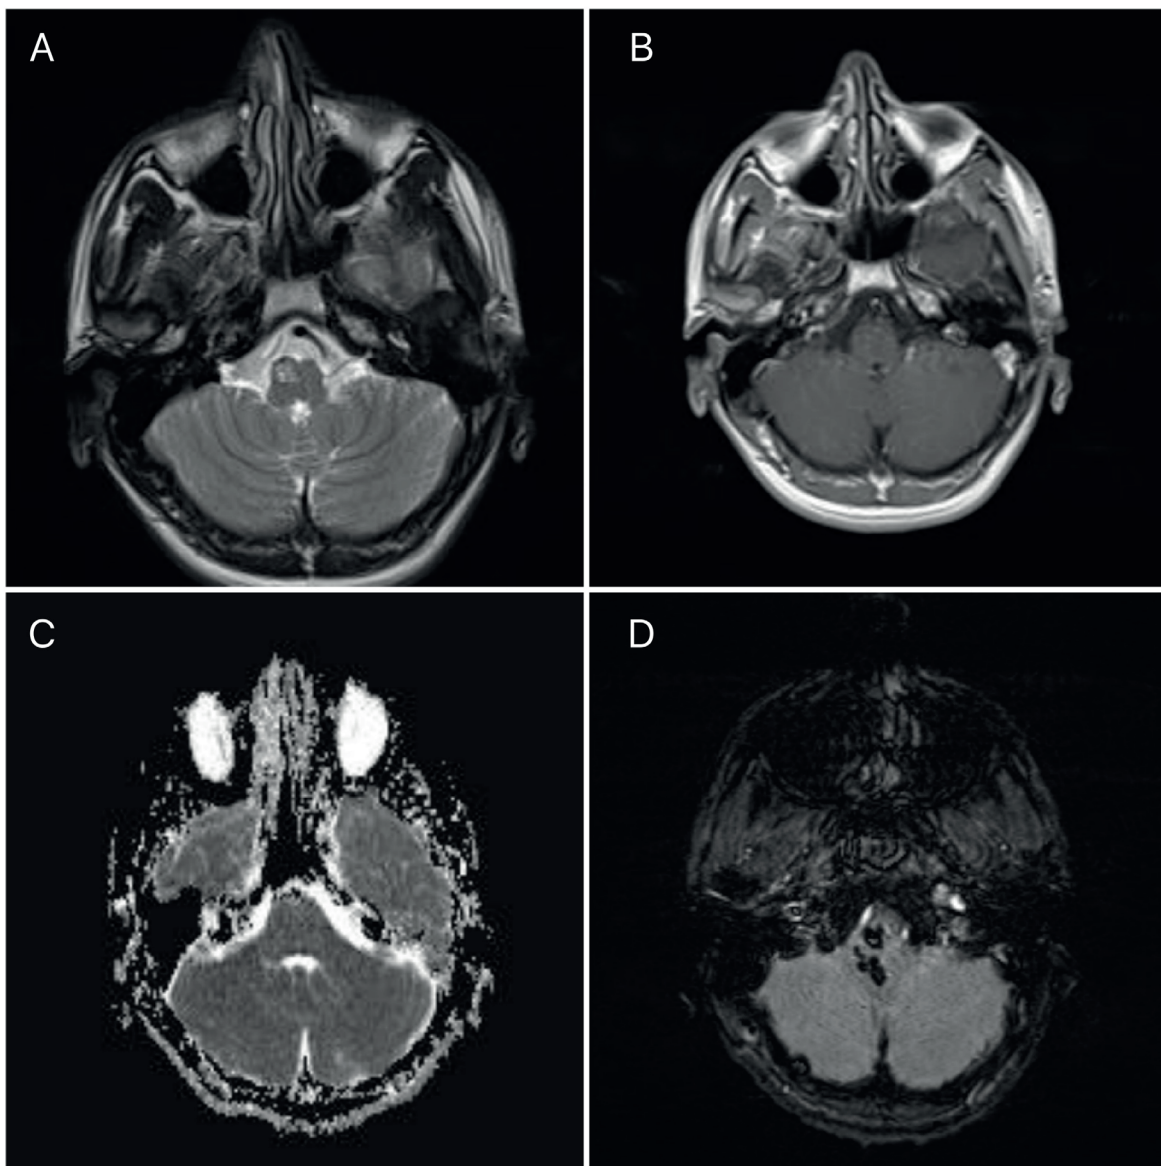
a. Axial T2WI shows increased signal and enlargement of right inferior olivary nuclei. b. Axial T1WI shows hypointensity in right inferior olivary nuclei with no enhancement on contrast enhanced MRI. c. Axial apparent diffusion coefficient (ADC) image shows shows enlarged hyperintense inferior olivary nucleus with no diffusion restriction. d. SWI sequences shows a chronic hemorrhage involving the medulla oblongata and cerebellum.
